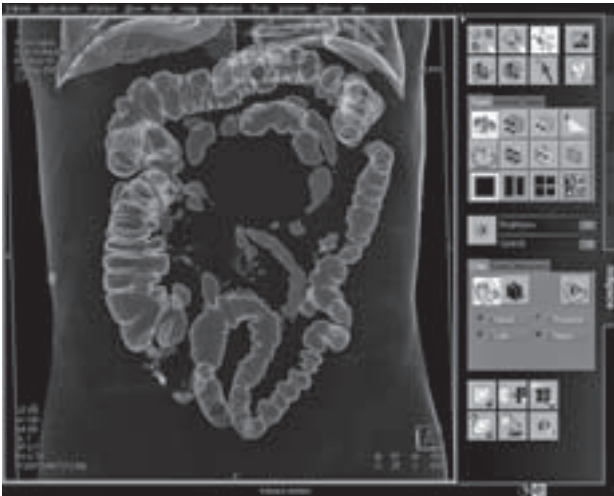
3DVR double air contrast reconstruction was performed after the air insufflation into the rectum. It may be used to estimate whether the air insufflation was successful. Furthermore, this method gives a general overview of the anatomical relationships of the large and partially of the small bowel. It is useful for clinicians to perform double air 3DVR before actual virtual colonoscopy or CT colonography because it may provide information which may be used by the clinician to make decision where to focus his attention during the virtual colonoscopy procedure. Sometimes cancer of a medium or large size may be revealed with this procedure. Relatively well colonic distention and cleansing in the 46-year-old man was shown.
